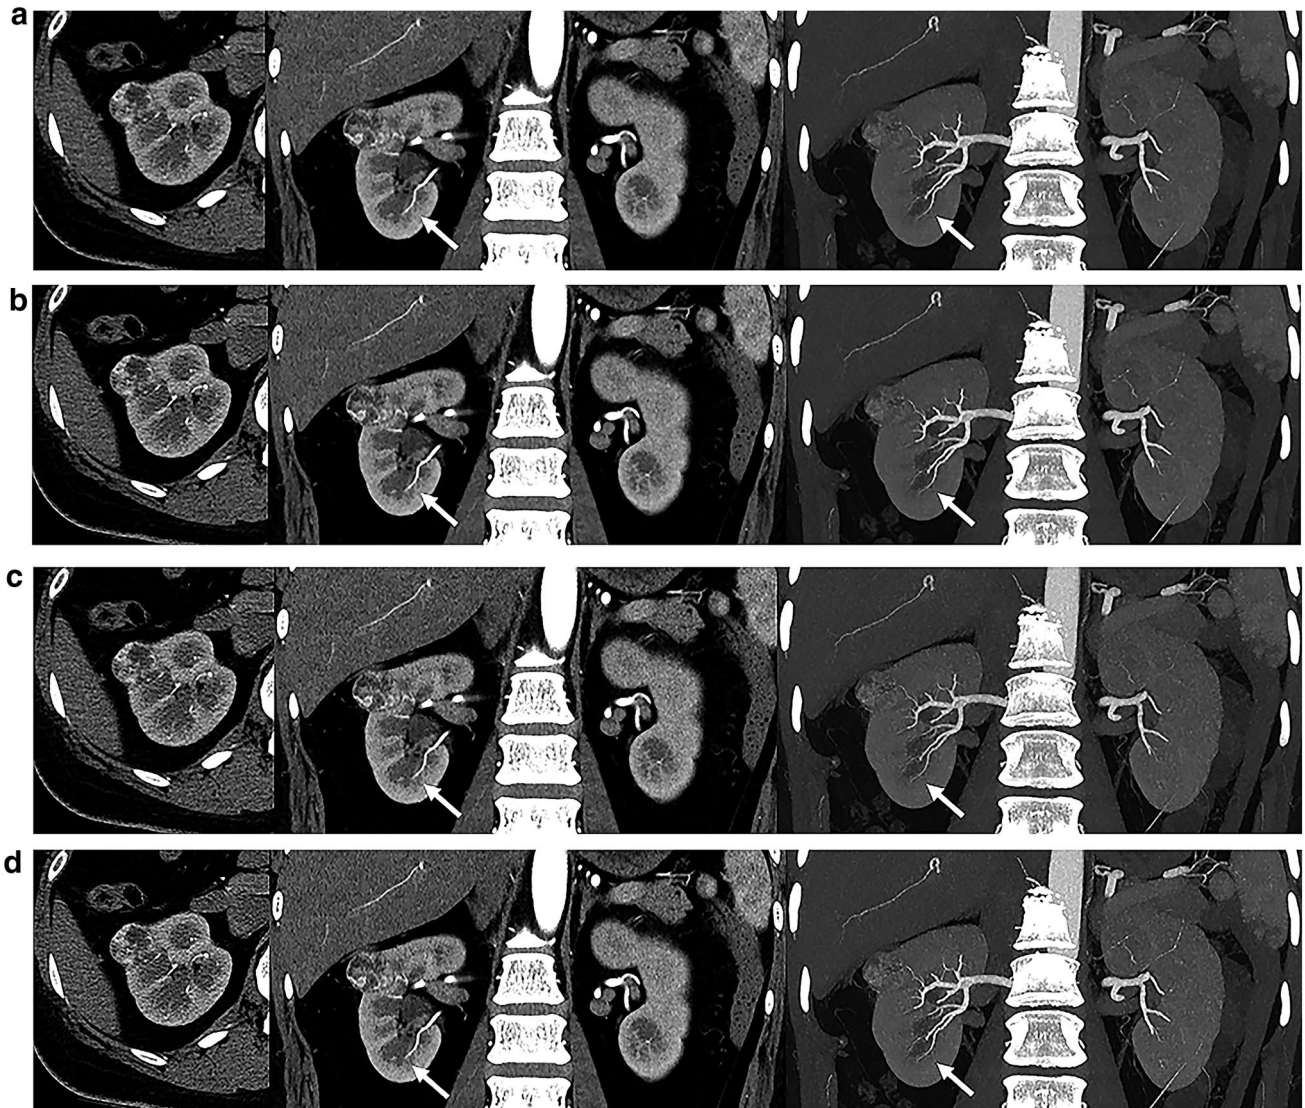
UHR-CT images in 39-year old female patient with right renal cell carcinoma (L to R: axial CT image, coronal multiplanar reconstruction image and coronal maximum intensity projection image). a UHR-CT reconstructed with hybrid-type IR method as 512 matrix shows right inferior segmental artery and interlobar artery (arrow), and was assessed as 3. b UHR-CT reconstructed with DLR method as 512 matrix shows right inferior segmental artery and interlobar
